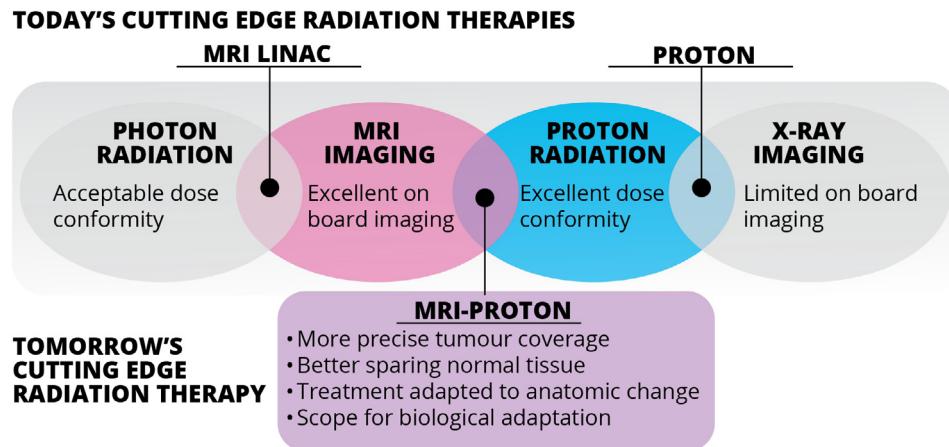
MRI-guided proton therapy combines two fast-growing technologies in radiation therapy. However, the integration of the two technologies is fraught with challenges.
